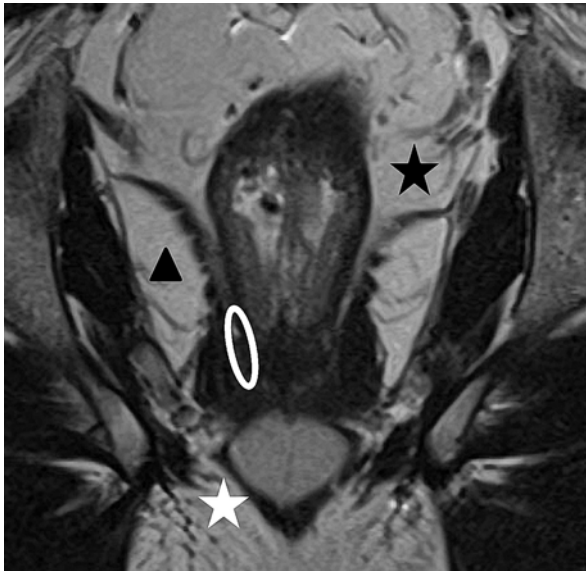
Coronal T2-weighted MR image showing the classification of anorectal abscesses by location. Supralelevator abscesses (*black star*) are located along the rectal wall cephalad to the levator musculature. Intersphincteric abscesses are located in a potential space, between the internal and external sphincters (*white oval*). Ischiorectal abscesses are located in the ischiorectal fossa (*black triangle*). Perianal abscess, the most common form of anorectal abscess, is located between the sphincter complex and the anal verge (*white star*)
